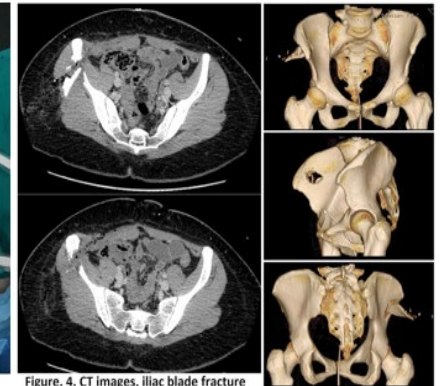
CT images, iliac blade fracture
